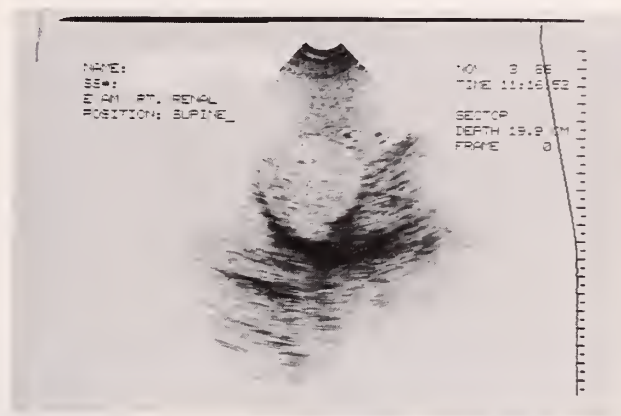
Solid hepatic mass detected incidentally on renal sonography.
